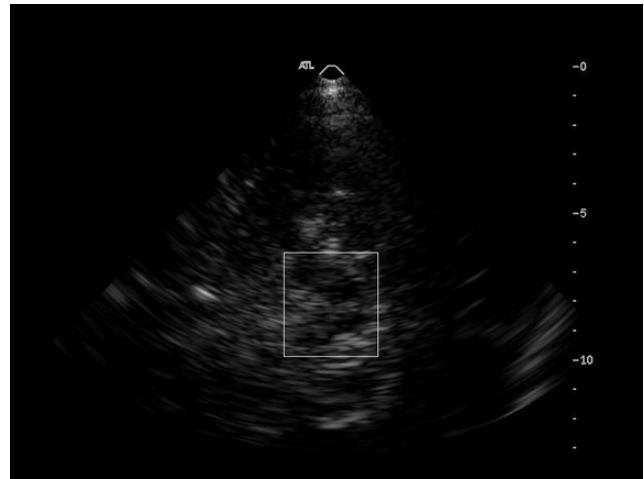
A highlighted position of SN in brain stem ultrasound image
